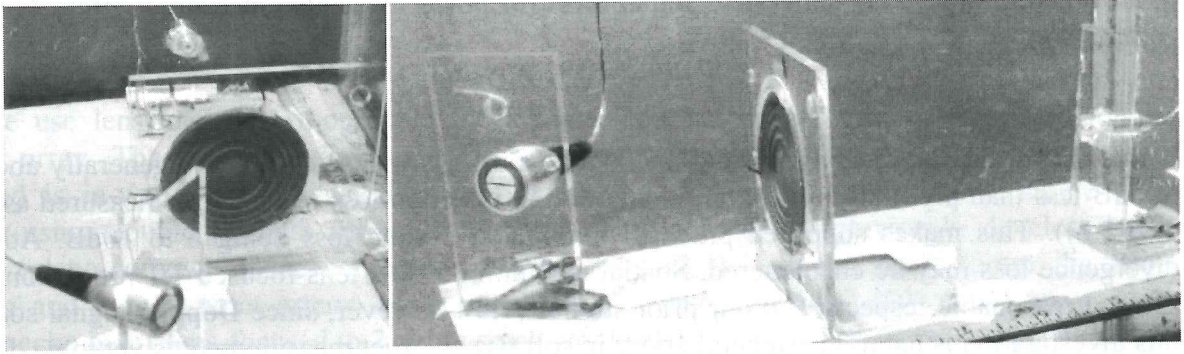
Experimental water vessel setup view. Flat PZT rejection transducer (left, oblique) is in origin half disc pair Doppler transducer, the 2 elements are used in parallel to make one flat disc projector.
